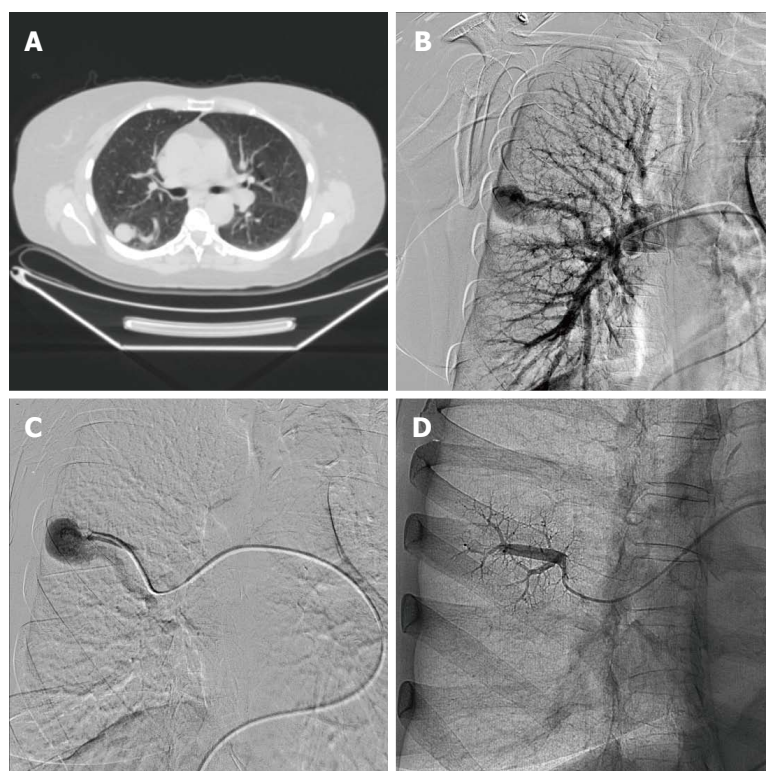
Pulmonary arteriovenous malformations. A: Computed tomography of the chest with large pulmonary arteriovenous malformation (PAVM) in the lower lobe of the right lung; B: Pulmonary angiogram of the PAVM in the same patient; C: Selective pulmonary angiogram of the PAVM in the apex of the lower lobe of the right lung; D: Repeat angiogram after transcatheter embolisation of the PAVM with a vascular plug.
